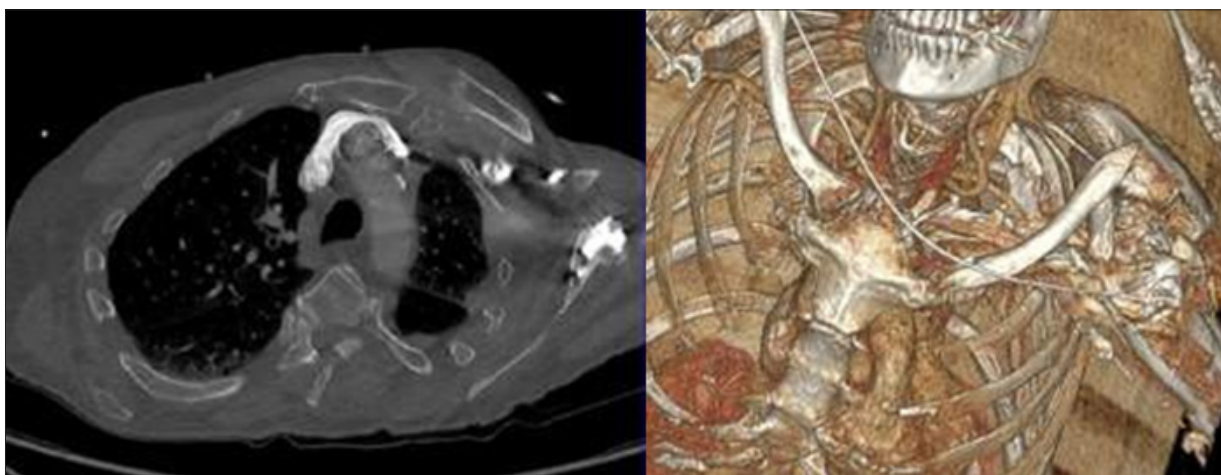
Initial Thoracic CT: Internal quarter fracture of left clavicle
